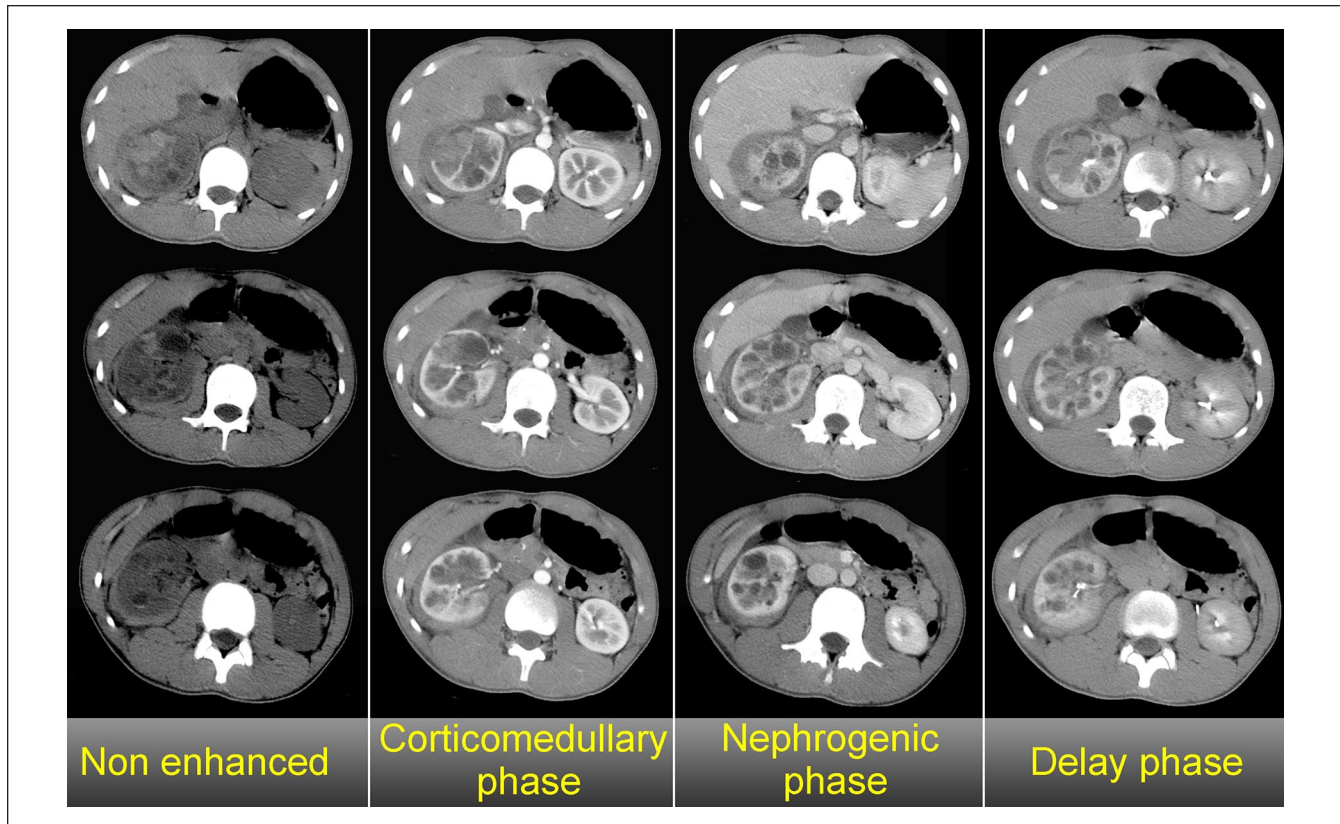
CT unenhanced phase and contrast-enhanced phase images showed multiple variably sized cysts in the mild enlarged right kidney separated by contrast-enhanced normal parenchyma. The images showed hemorrhagic contusion and laceration in the upper polar of the right kidney with subcapsular hematoma. The appearance of the left kidney was normal. Abbreviation: CT, computed tomography.
